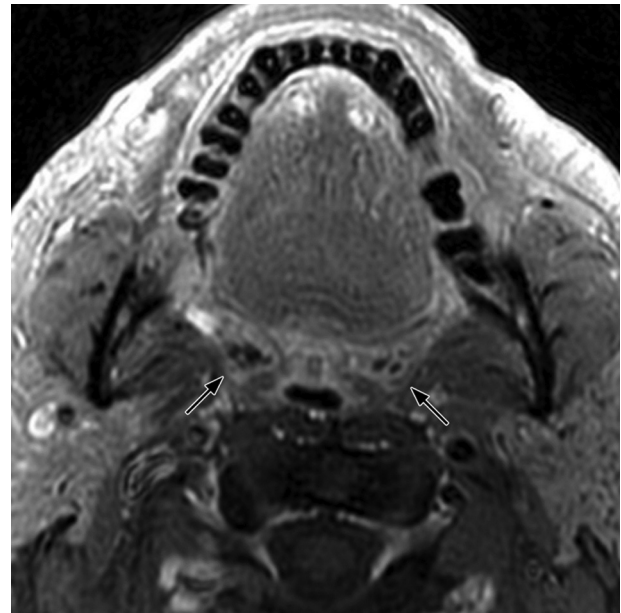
Cervical T1-weighted fat-suppressed MR image in the transverse plane obtained after IV administration of a gadolinium chelate shows foci of signal void located in the right and left palatine tonsils (arrows).
